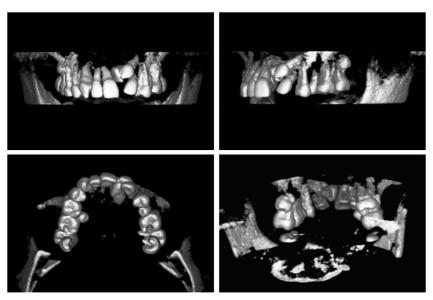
Pretreatment CBCT images showing the deeply impacted tooth 21 and buccally impacted tooth 23. The crown of the transposed tooth 23 situated buccally to the root of tooth 22 but palatally to the crown of tooth 22.
